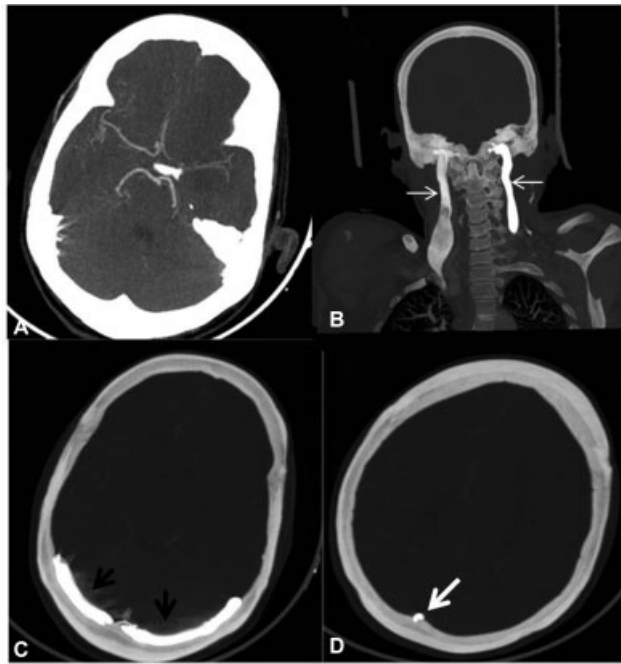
(A) Axial computed tomography (CT) angiography source images show normal opacification of circle of Willis in arterial phase. (B) Coronal CT images with wide window setting show opacification of bilateral jugular veins (white thin arrows) due to reflux. (C) Axial CT image with wide window setting shows reflux into bilateral transverse sinuses (black arrows). (D) Axial CT image with wide window setting shows reflux into posterior part of superior sagittal sinus.
